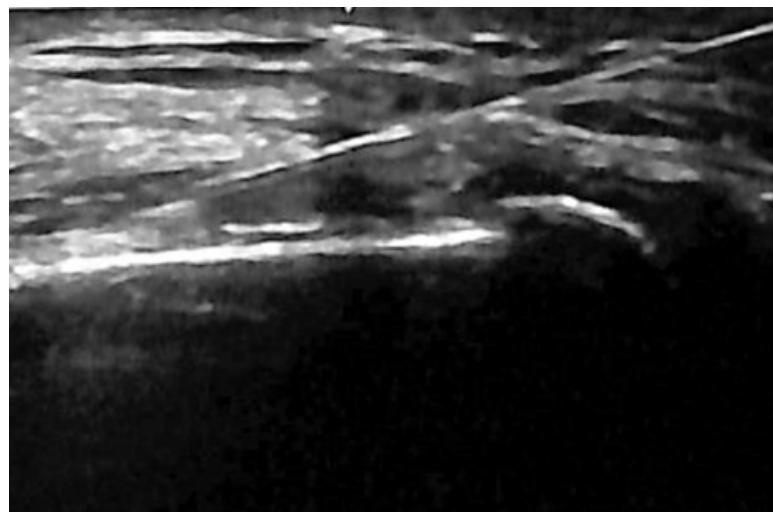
Ultrasound-guided Hypertonic Dextrose Injection at the Lateral Collateral Ligament Insertion
